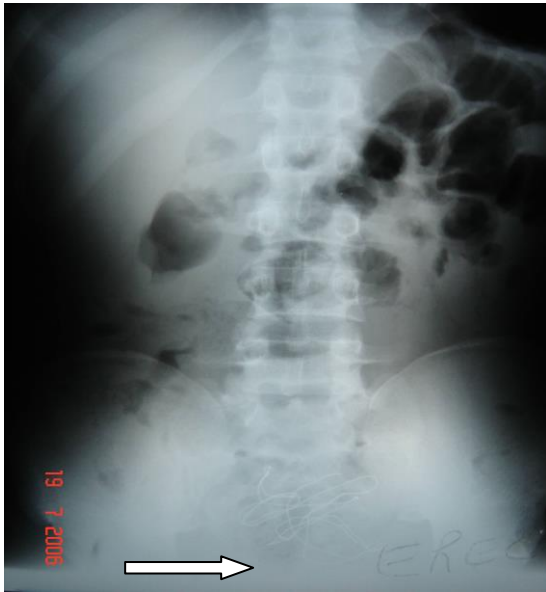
shows the abdominal x-ray of patient described in 4.2 Clinical vignette (above). Note the opacity indicated by the arrow.
